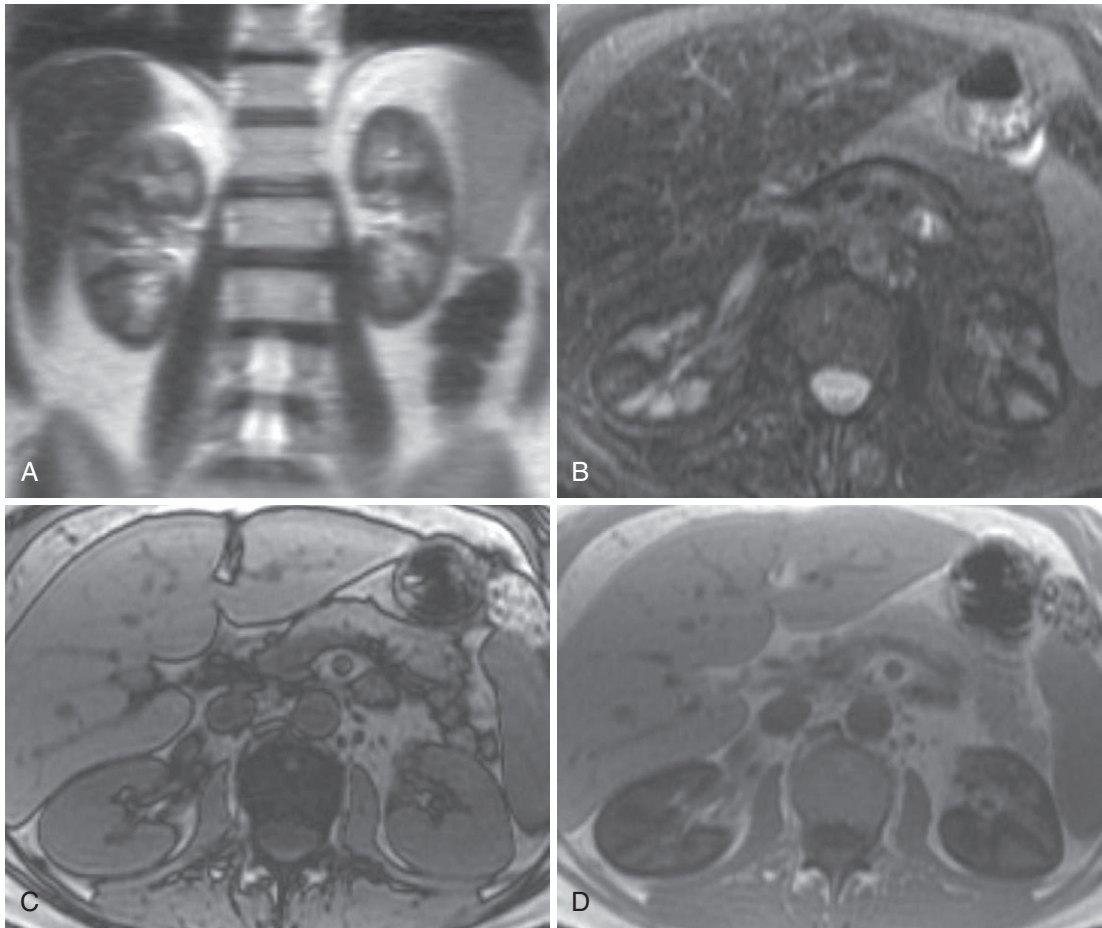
Mechanical hemolysis. Coronal T2-weighted (A) and axial T2-weighted fat-suppressed (B) images reveal marked hypointensity restricted to the renal cortex, not apparent on the out-of-phase image (C). D, Pronounced cortical signal loss on the in-phase image connotes susceptibility artifact due to hemosiderin deposition.
